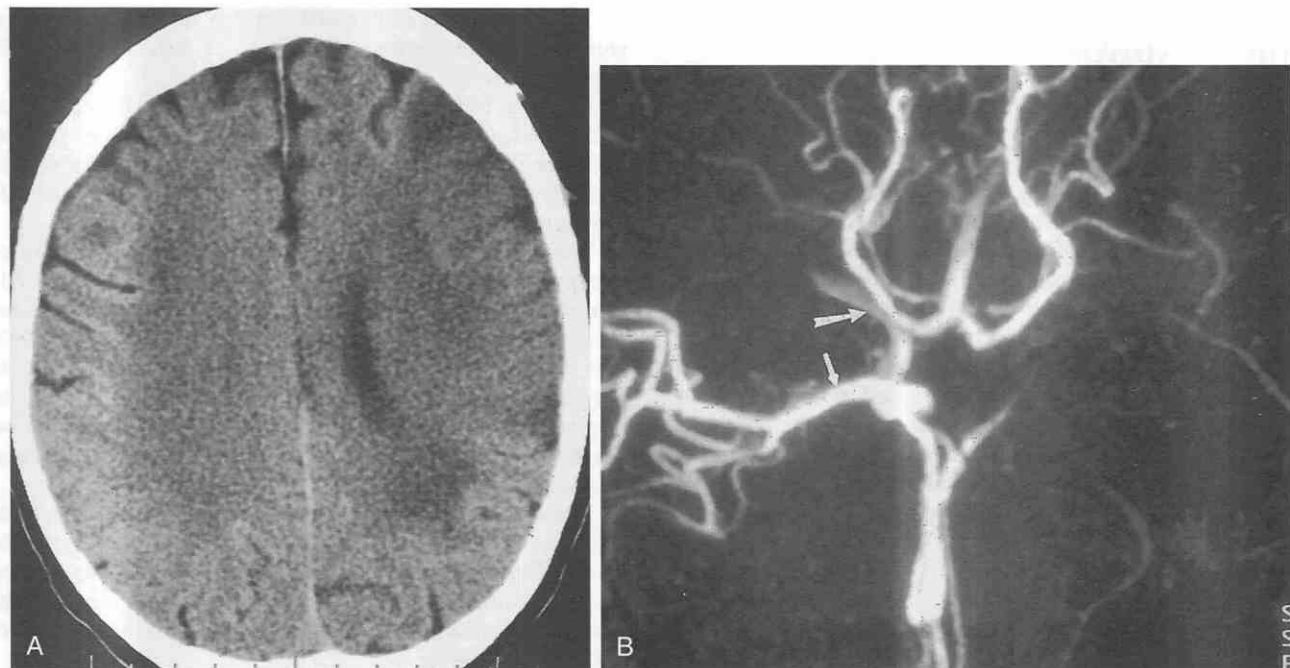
Acute aphasia and right-sided weakness. *A*, Unenhanced CT scan shows low density, loss of gray matter–white matter contrast, and effacement of sulci within the territory of the left middle cerebral artery. *B*, Maximum intensity projection image (anterior displayed at the bottom of the image) from intracranial 3D time-of-flight MRA shows no signal within the left middle cerebral artery or the left internal carotid artery. The normal appearance of the right internal carotid artery (arrow) and the middle cerebral artery (small arrow) is well visualized by comparison.
